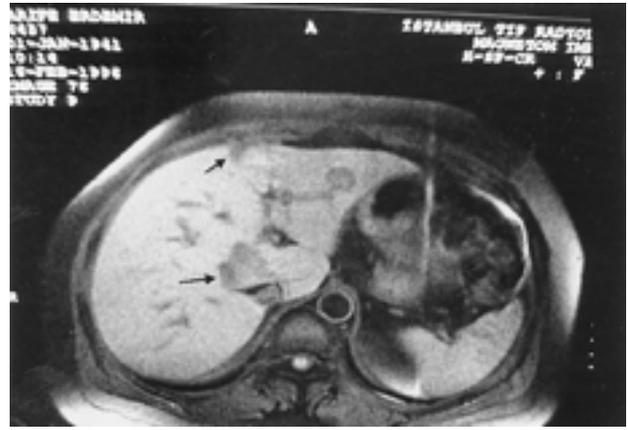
MRI fat-saturation sequence of the image in Figure 2 (February 1996)
